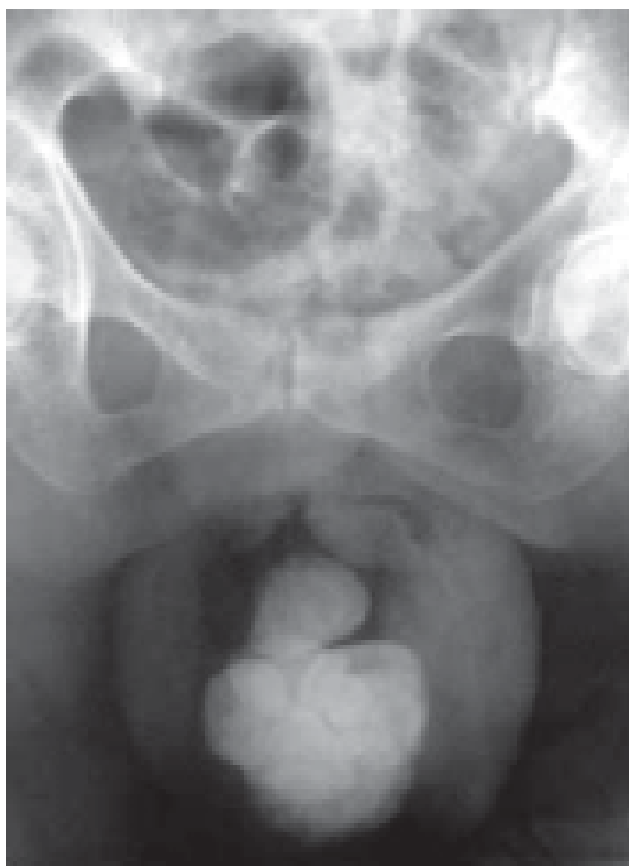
X-ray showing the calcification of the prolapsed mass
